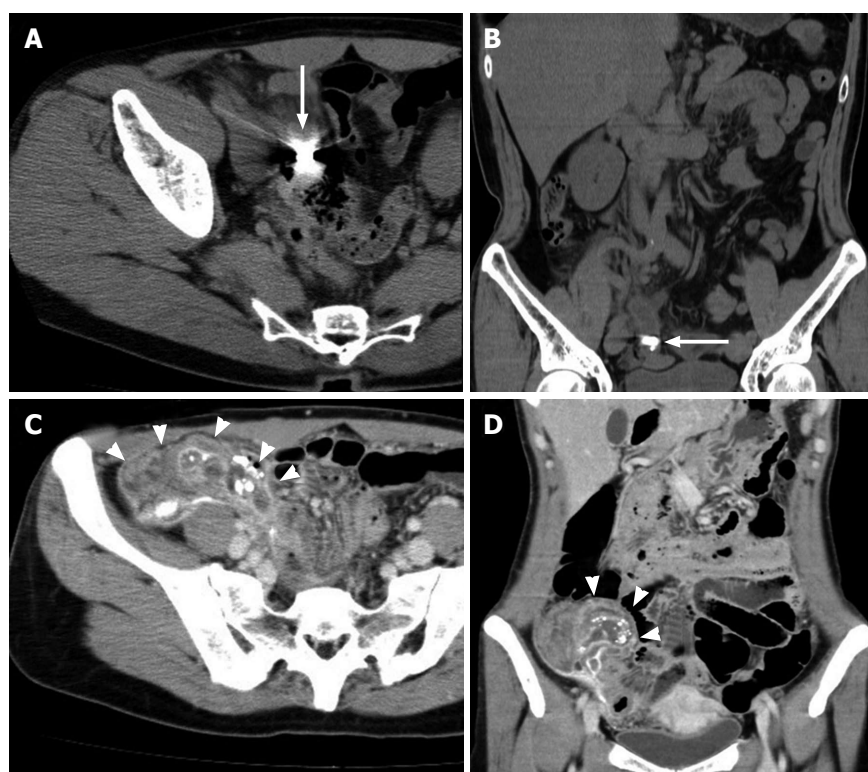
Abdominal computed tomography scans with axial and coronal views. A and B: High density material is seen inside the swollen appendix (arrows); C and D: High density material is seen inside the swollen appendix and in the peritoneal cavity with a fluid collection (arrow heads). This strongly suggests a perforated appendicitis with residual barium.
